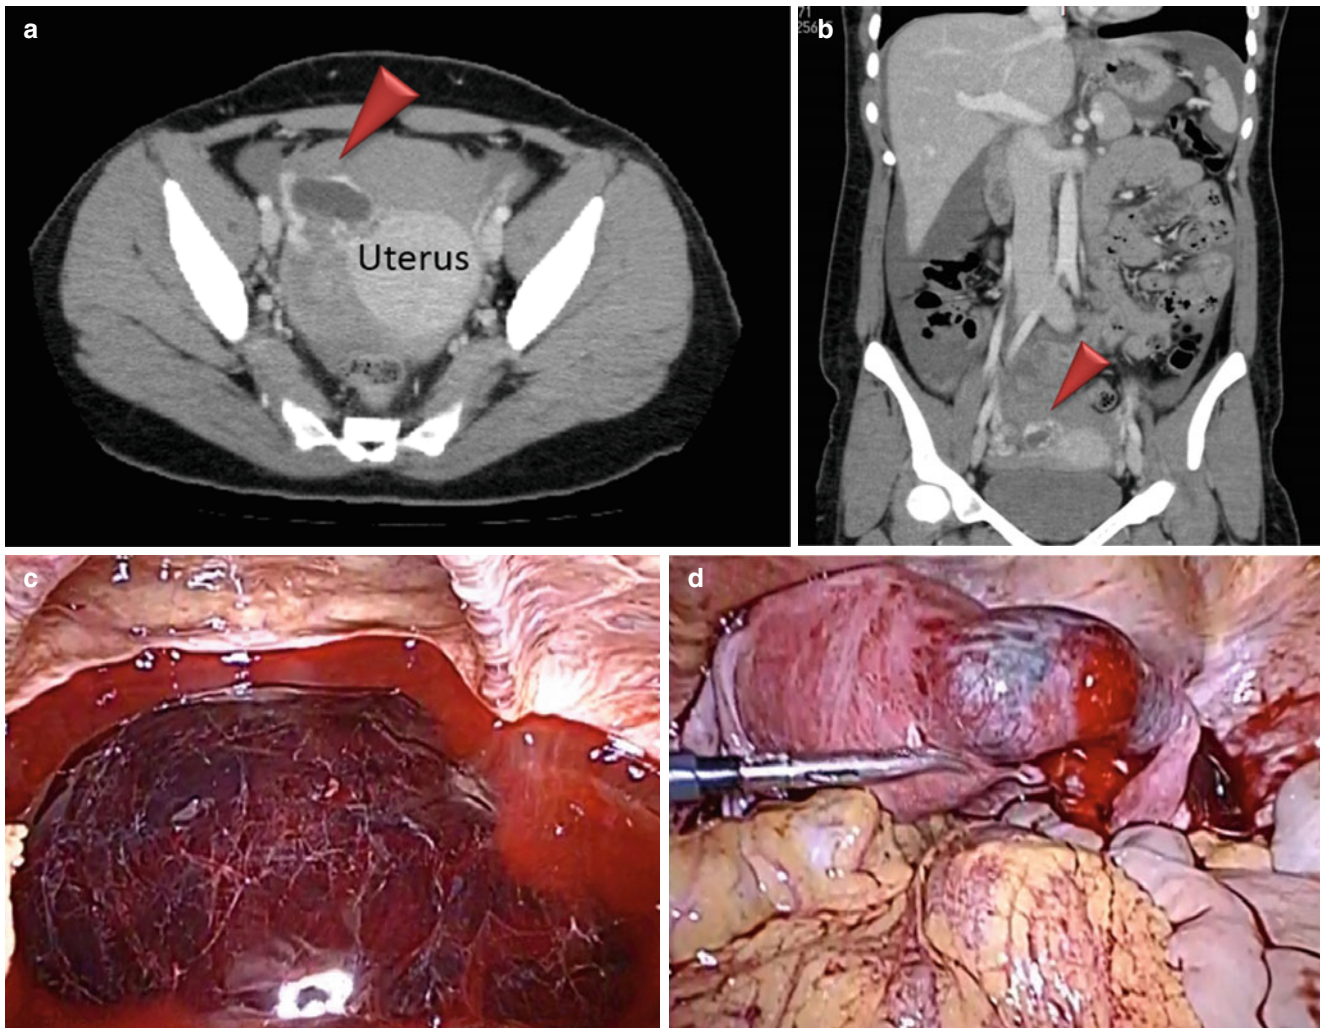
Patient with ruptured tubal pregnancy. Computed tomography revealing isodense areas of severe hemoperitoneum around the uterus (a) and the spleen and liver (b). The dilated left tubal isthmus
